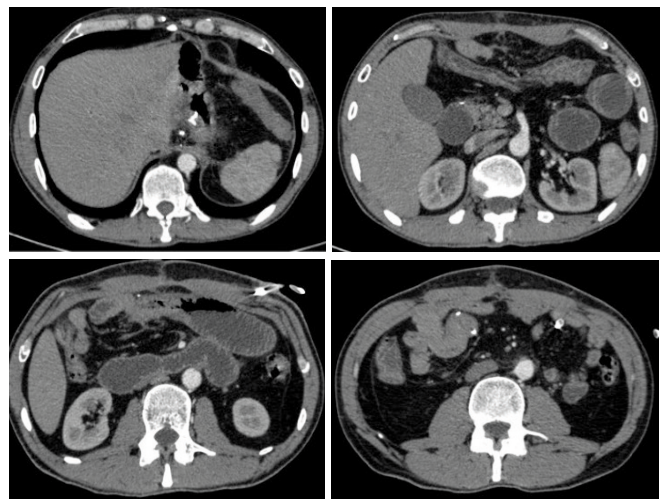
Selected axial post-contrast CT images of the abdomen.
